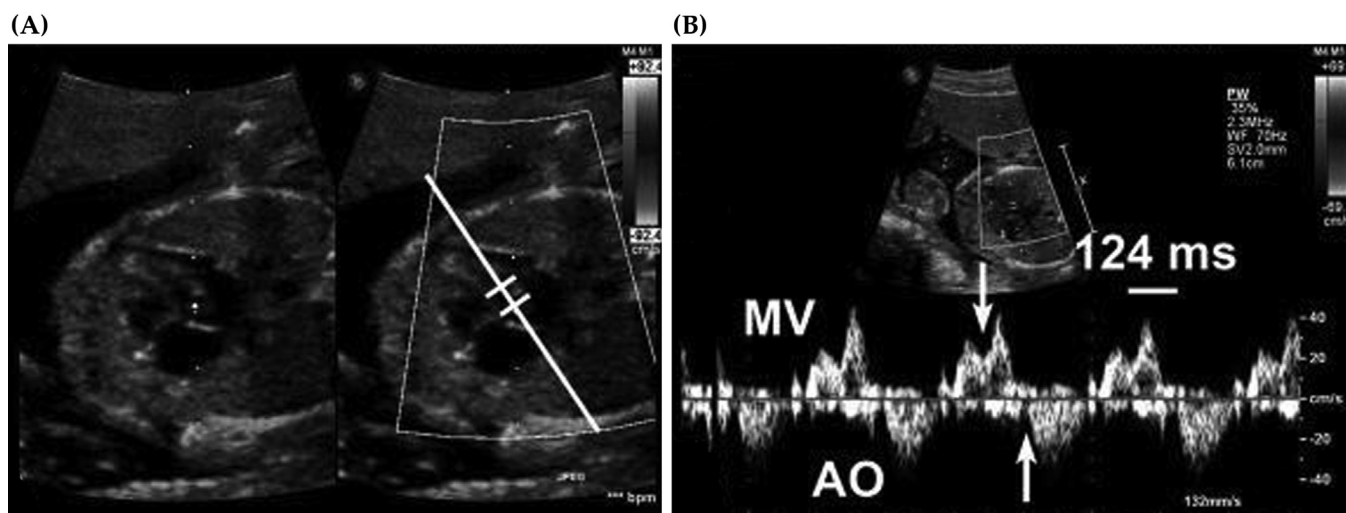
Obtaining mechanical PR interval on fetal echo. Mitral-aorta pulsed-wave Doppler method. The Mitral (MV)-aorta (AO) method relies on identification of the trans-mitral atrial inflow (A wave) and ejection out the left ventricular outflow tract. The Doppler pulsed-wave sample volume is placed near the mitral valve leaflet in the left ventricle (LV) outflow tract (panel A), and measurement is made from the onset of the trans-mitral A wave to the onset of LV outflow tract ejection (panel B, arrows). In this case, the MV-AO PR interval is 124 ms. Note: The mechanical PR interval may not reflect only the true electrical PR interval, as mechanical and flow events may also influence this measurement; a discussion is beyond the scope of this chapter but the reader is referred to the review by Phoon et al. for further discussion on the strengths and weaknesses of various methods. Adapted from Phoon et al. [78].
